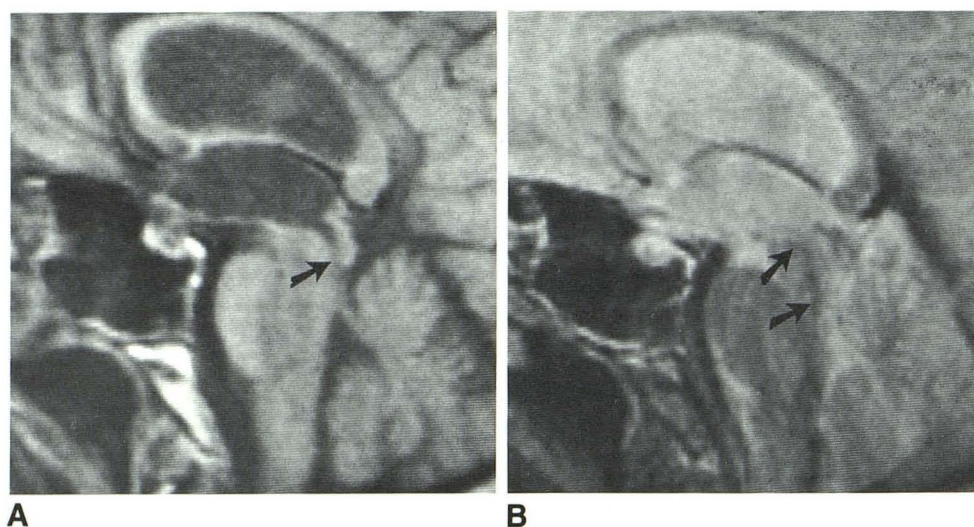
77-year-old man with cerebral atrophy. Midsagittal scans are 5 mm thick. A, T1-weighted (SE 750/40). Dilated lateral and third ventricles. Caudal segment of aqueduct of Sylvius is poorly seen (arrow). B, T2-weighted (SE 2300/80). CFVS is present (arrows), indicating patency of aqueduct of Sylvius. Limited pneumoencephalogram confirmed patency of aqueduct of Sylvius.
